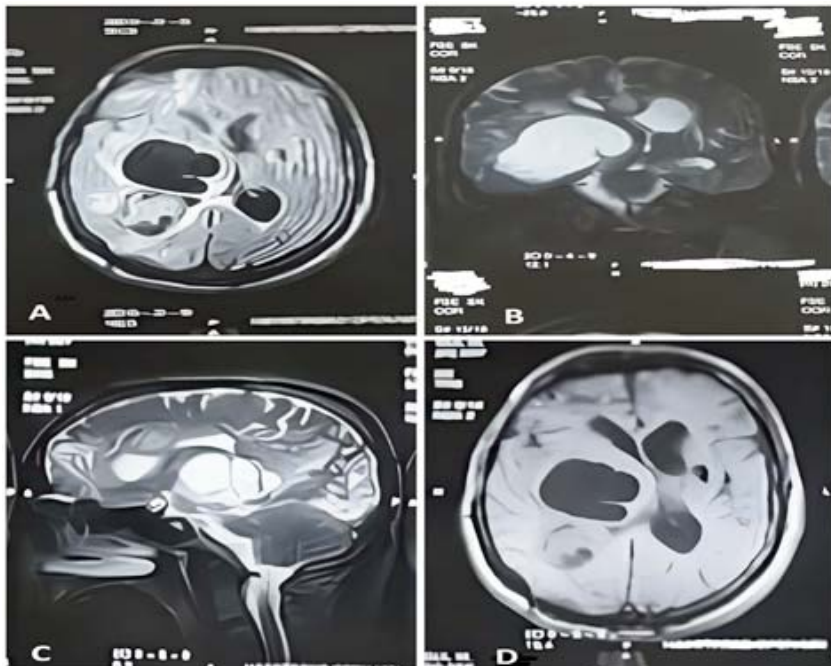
Preoperative magnetic resonance imaging showing multiple intracranial cystic lesions; (A) axial, flair MRI sequence; (B&C) T2-weighted, coronal and sagittal sections and (D) T1-weighted, contrast enhanced axial sequence.
